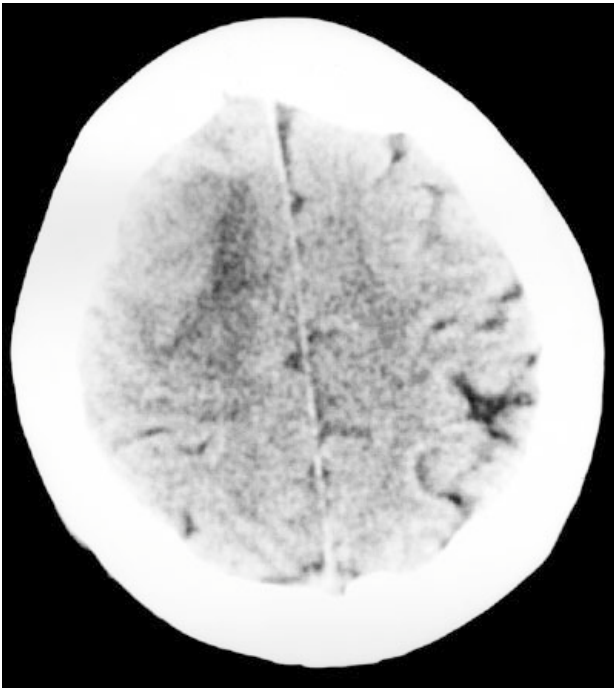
Axial CT scan revealing a subtle, poorly-defined, non-specific, hypodense area in the right high frontal lobe with effacement of the adjacent cerebral sulci.
